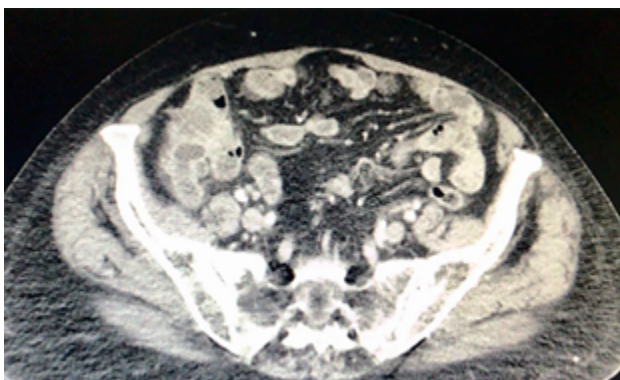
Abdominal CT shows the relationship of the tumor to the anterior abdominal wall.
